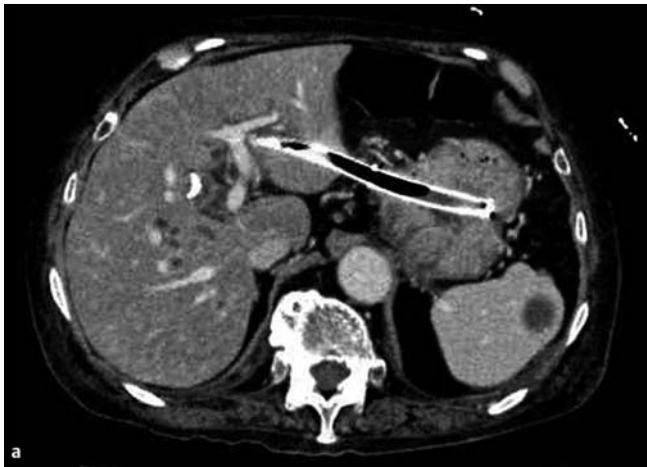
Protrusion into the stomach of the long self-expandable metal stent (SEMS) used for endoscopic ultrasound-guided hepaticogastrostomy (EUS-HGS): a on computed tomography (CT) scan; b on endoscopy.
